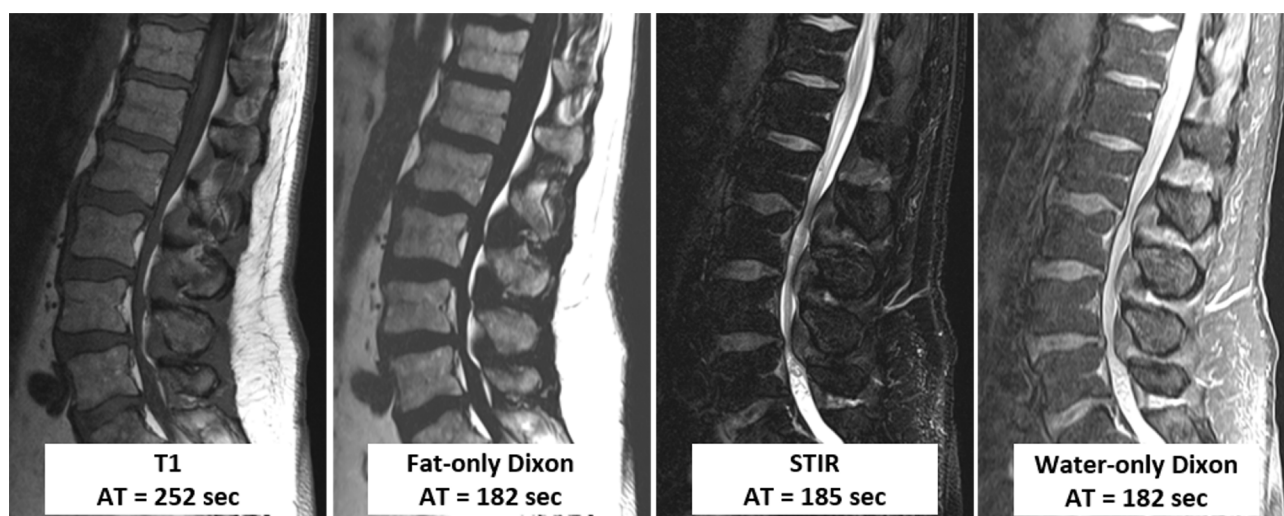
MR images of the lumbar spine in a 67-year-old man. Note increased SNR of the water-only Dixon relative to STIR. No areas of failed FS are evident on STIR or water-only Dixon. A fat-only Dixon is demonstrated which provides additional utility in marrow assessment. Taken together, the fat-only Dixon and in-phase Dixon (not shown) could obviate the need to acquire T1-weighted sequences. AT = acquisition time.
